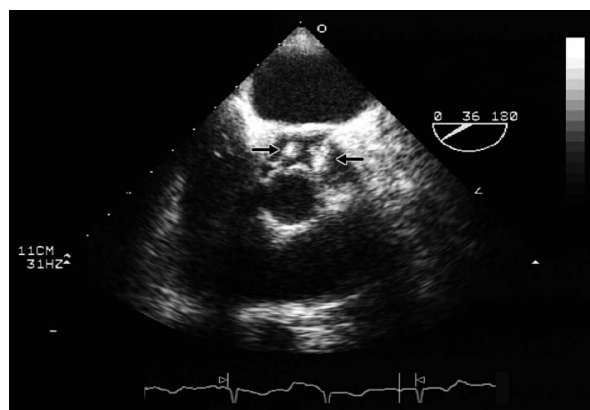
Transesophageal echocardiogram in transverse plane shows vegetations on the left coronary and the non-coronary cusps of the aortic valves (arrows).
